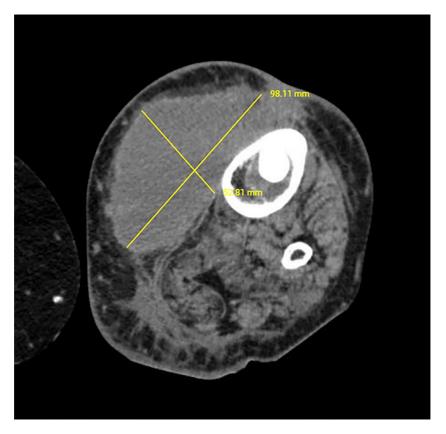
Computed tomography (CT) scan of the left knee demonstrating joint effusion and large collection. The lines drawn in yellow delimit the anteroposterior diameter of the collection and its transverse diameter, which are the values used for volumetric measurement of the abscess.
